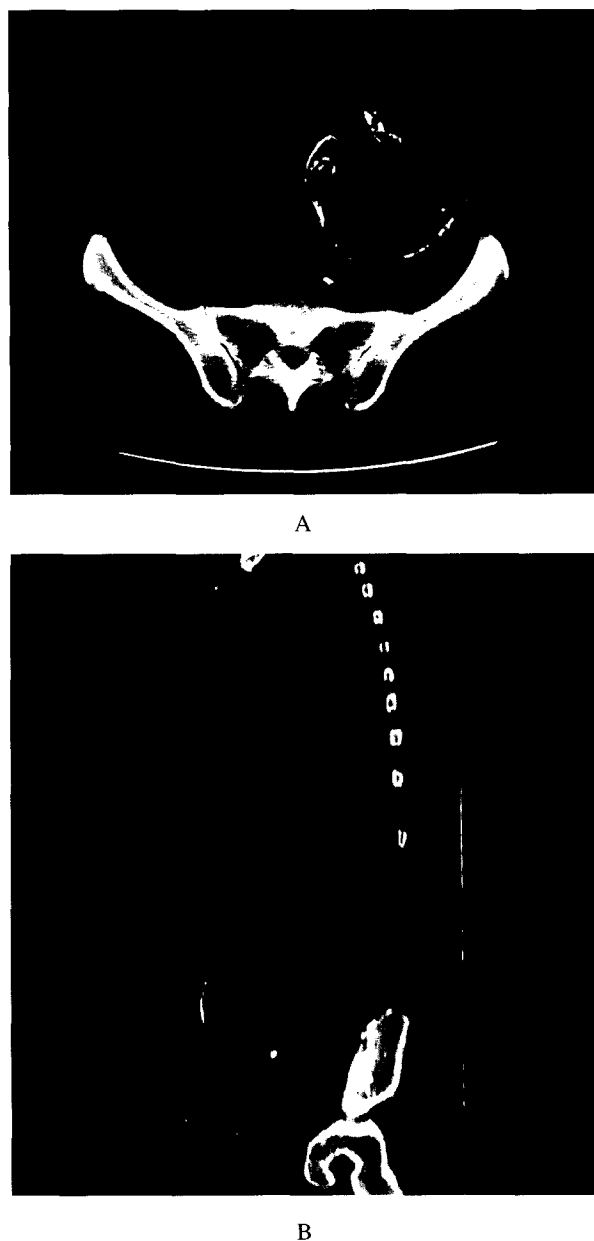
44-year-old man with chronically rejected renal allograft. Axial (A) and sagittal (B) CT without contrast enhancement revealed the transplanted kidney at left pelvic fossa was replaced by a huge mass with obvious anterior protuberance. Some dense amorphous calcification in the mass was noted. The native left kidney was atrophic (arrow).
